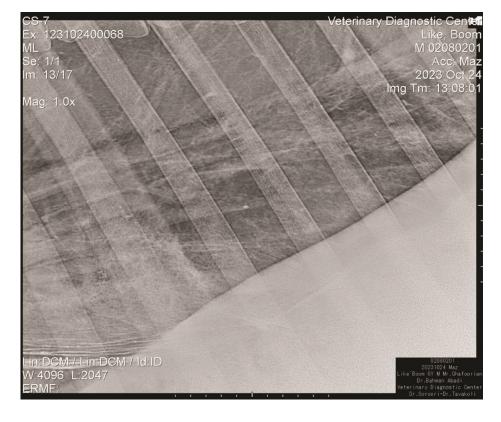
Lateral radiograph of the thoracic region of a 6-year-old Friesian Stallion
